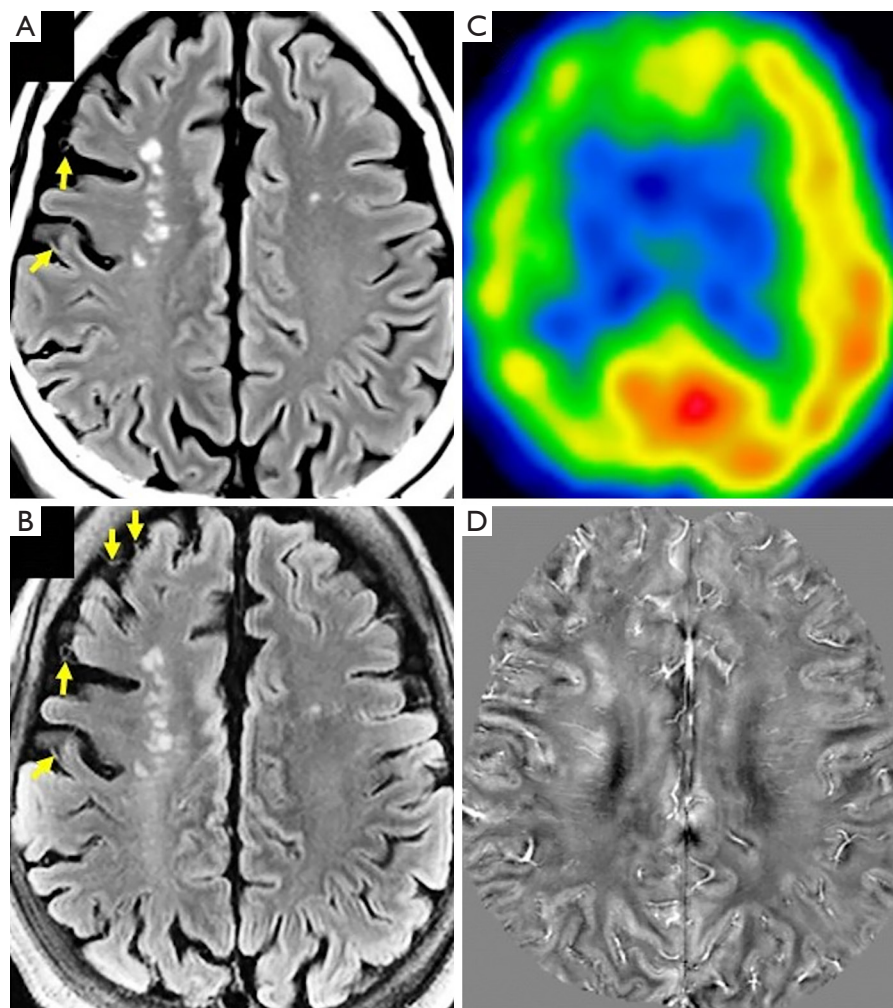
The same patient as in *Figure 12*. FLAIR images acquired at 3T (A) and 7T (B). Both images show similar white-matter lesions as hyperintense, but “ivy-signs”, representing slow collateral flow, are better depicted at 7T (arrows). (C) CBF measured using iodine-123 N-isopropyl-p-iodoamphetamine SPECT at rest. CBF is widely lower on the right frontal area. (D) QSM acquired at 7T (0.5 mm isotropic resolution) shows increased susceptibility at the cortex, medullary veins, and ischemic lesions in the same area. The right side of the images shows the left side of the patient. CBF, cerebral blood flow; FLAIR, fluid-attenuated inversion recovery; 3T, 3 Tesla; 7T, 7 Tesla; SPECT, single-photon emission computed tomography; QSM, quantitative susceptibility mapping.
